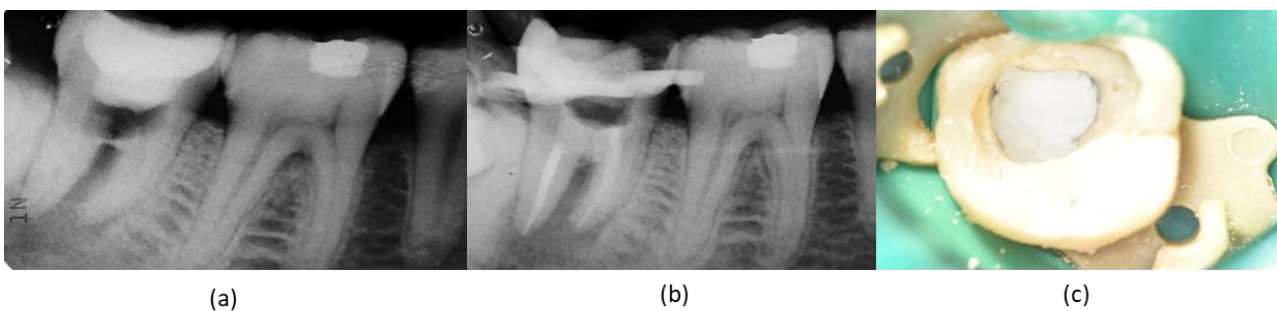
(a) Radiograph after the first attempt of repair showing thin placement of MTA over the perforation site. (b) Postoperative radiograph after the completion of NSRCT with 5mm placement of MTA over the perforation site. (c) Clinical pictures after the MTA placement that covers the whole obturated canals and perforation site.
